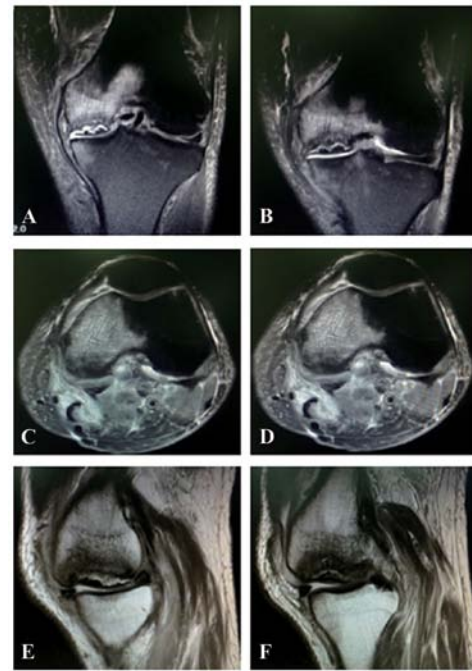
T2-weighted MRI images prior to the total knee arthroplasty surgery. (A) Coronal MRI through the intercondylar fossa: On imaging, the lesion was surrounded by a large hypointense area with diffuse bone marrow edema and collapse of the subchondral bone. (B) Coronal MRI through the post femoral condyle: On imaging the whole medial post femoral condyle was presented with diffuse bone marrow edema. (C) Sagittal MRI: On T2-weighted imaging, a large hypointense edematous area of the medial femoral condyle was observed, which was not present in the first MRI examination. (D) Another sagittal MRI on T2-weighted imaging showed the edematous area of the medial femoral condyle was larger and went through several sections. (E) The sagittal T2-weighted image revealed a crescent-shape area of low signal intensity indicating subchondral bone destruction within the medial femoral condyle. (F) The sagittal T2-weighted image showed the area of the subchondral bone destruction in the lateral femoral condyle became smaller than the medial femoral condyle.
